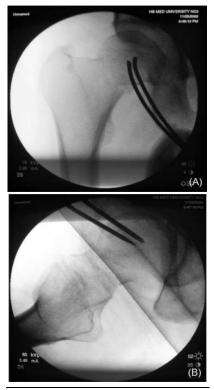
Pins inserted to the proximal segment guided by xray (C-arm)(A) and reduction checked by the C-arm (B)
